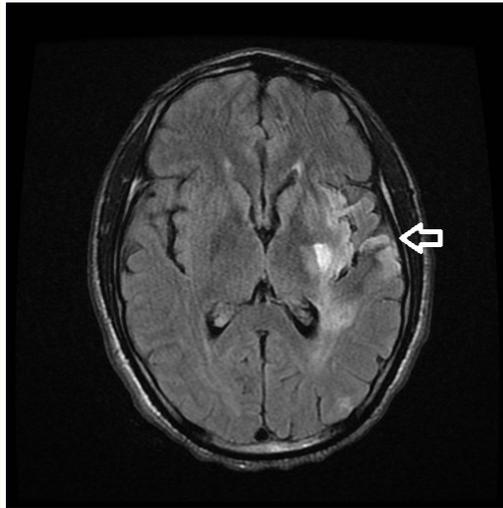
MRI brain , DWI and FLAIR sequences showing left parietal, temporal and insular cortex infarction.
